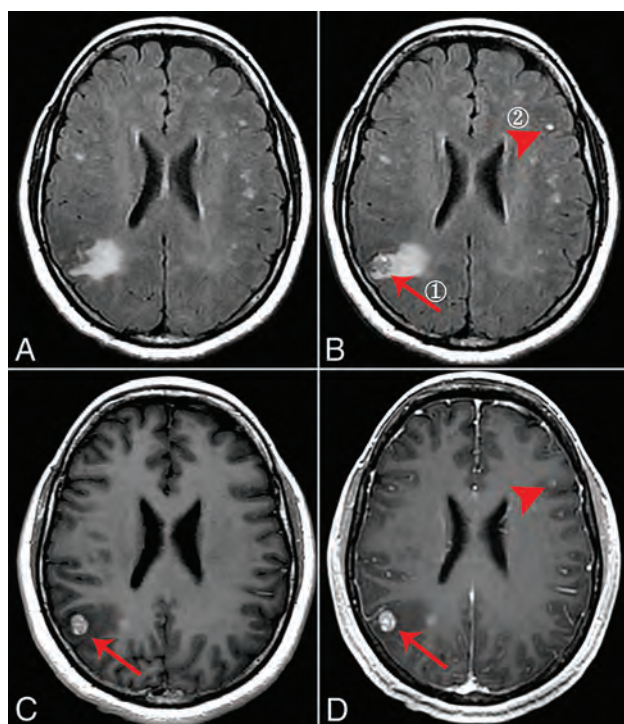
A 48-year-old man with solid brain metastases in the right parietal cortex (①, ≥ 5 mm, *arrow*) and left frontal cortex (②, < 5 mm, *arrowhead*). A, Nonenhanced T2 FLAIR. B, Phase 3 half-dose CE-T2 FLAIR (①, 1 point; ②, 3 points). C, Half-dose CE-T1WI (①, 3 points; ②, missed diagnosis). D, Routine-dose CE-BRAVO (①, 3 points; ②, missed diagnosis).
